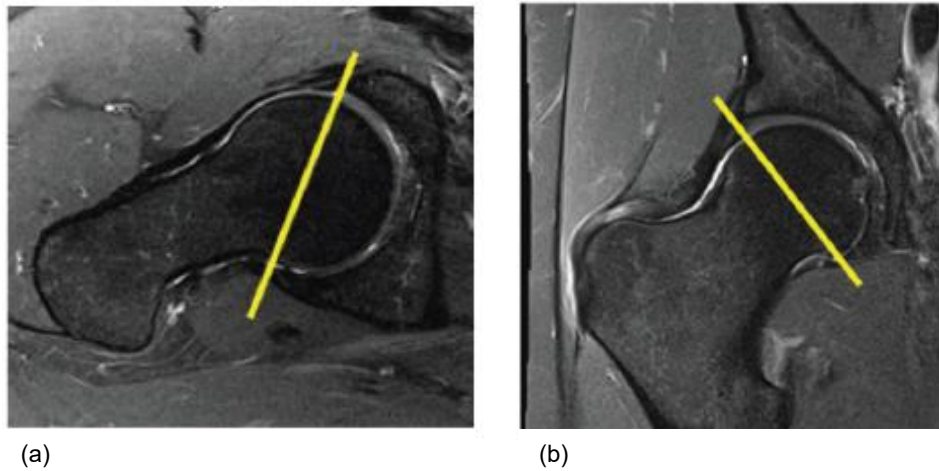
Radial MR images show that the acetabular opening is anteverted (yellow line in a) and inclined (yellow line in b). (Image from [28])
